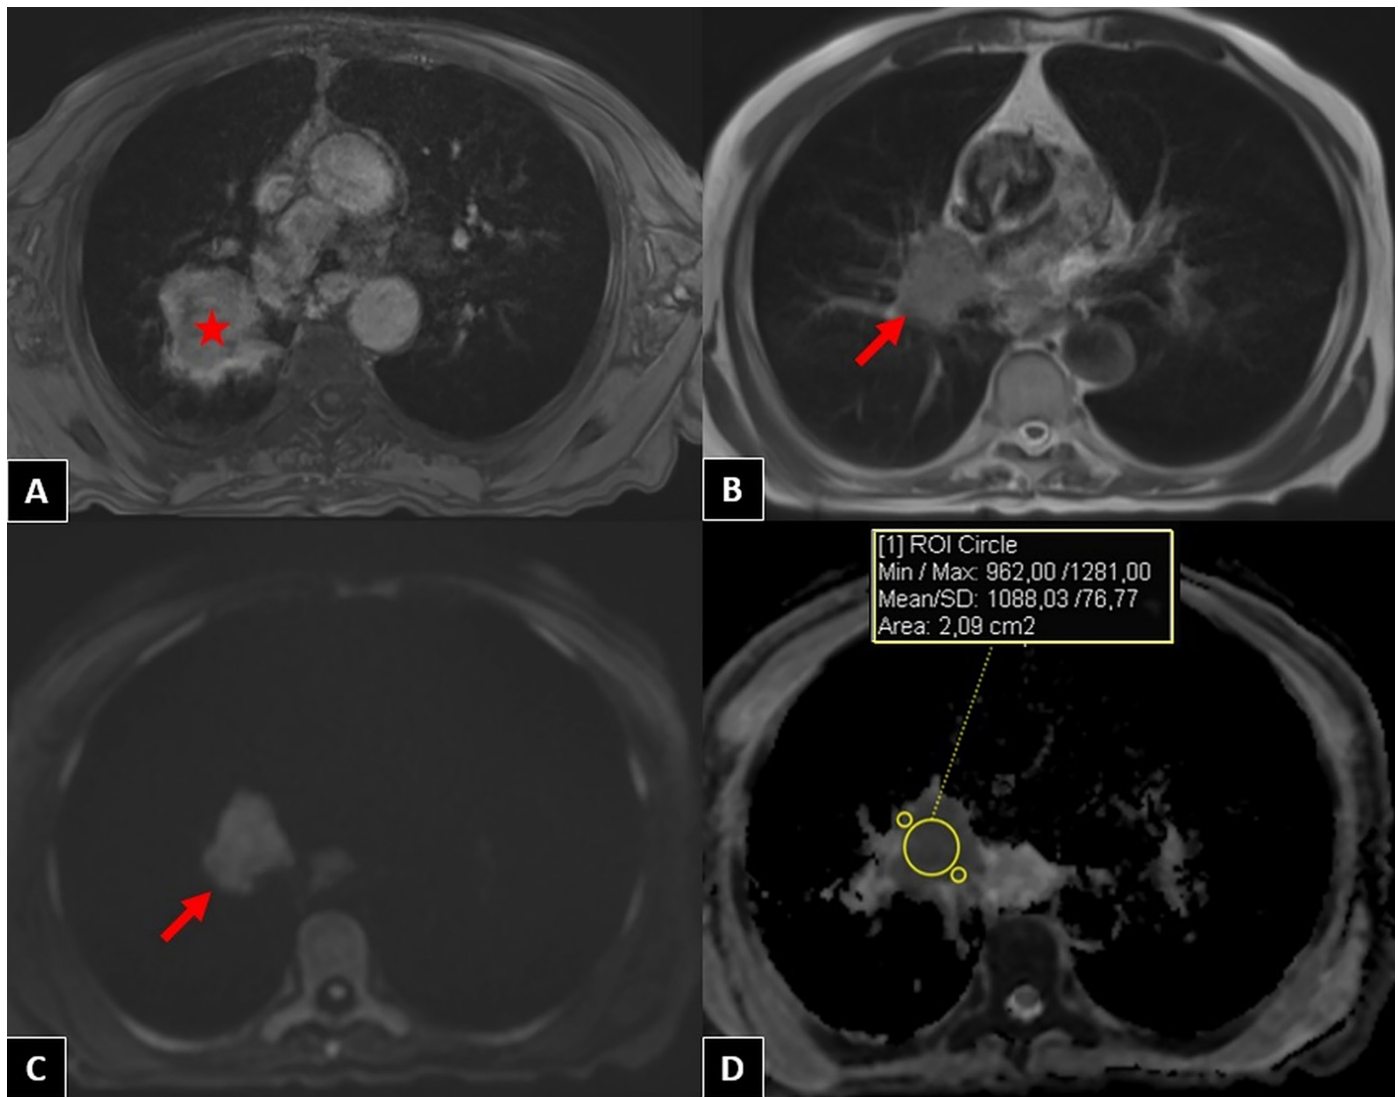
A 65-year-old patient with non-small cell lung cancer. (A) An axial post-contrast T1W magnetic resonance (MR) image shows a hyper-enhancing right upper lobe lung mass (red asterisk); (B) an axial T2W MR image shows right hilar lymphadenopathy (red arrow); (C) A $b=800 \text{ s/mm}^2$ diffusion-weighted MR image shows hyperintense right hilar lymphadenopathy (red arrow); (D) in the ADC map image, the mean ADC value of this lymph node was measured as $1.08 \times 10^{-3} \text{ mm}^2/\text{s}$.
